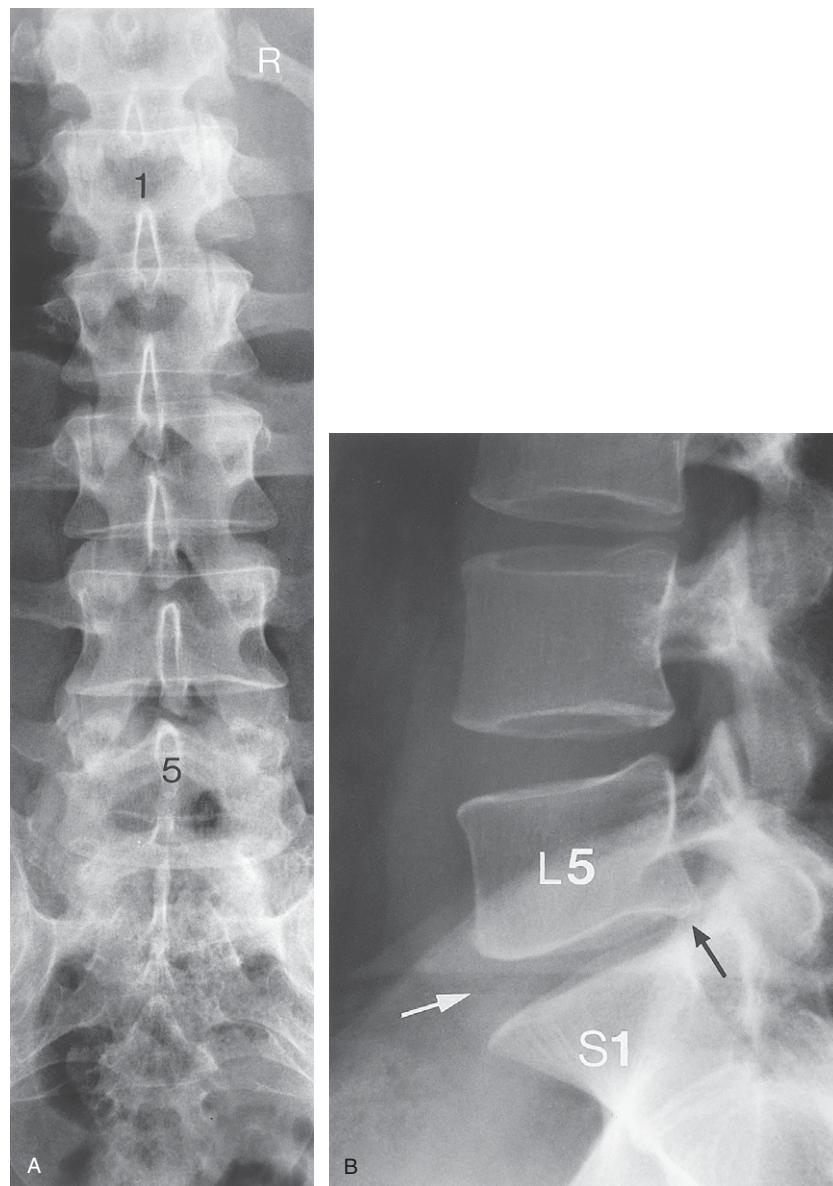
(A) Pelvis and lumbar spine anteroposterior (A-P) plain X-ray image (cropped and viewed from posterior to anterior). 1 = first lumbar vertebra, 5 = spinous process of fifth lumbar vertebra; R = right side of patient. (B) Lumbosacral spine lateral plain X-ray image. Note the L5-S1 disc height thinning (white arrow) as compared to the L4-5 disc space height above. Also, note the retrolisthesis (black arrow) of L5 on S1. L5 = fifth lumbar vertebra. S1 = first sacral segment.
